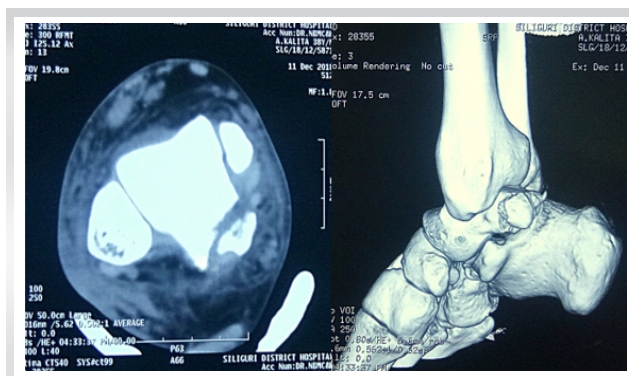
An axial cut section and a 3D reconstructed computed tomographic scan showing a posteromedial tubercle fracture of the talus.
